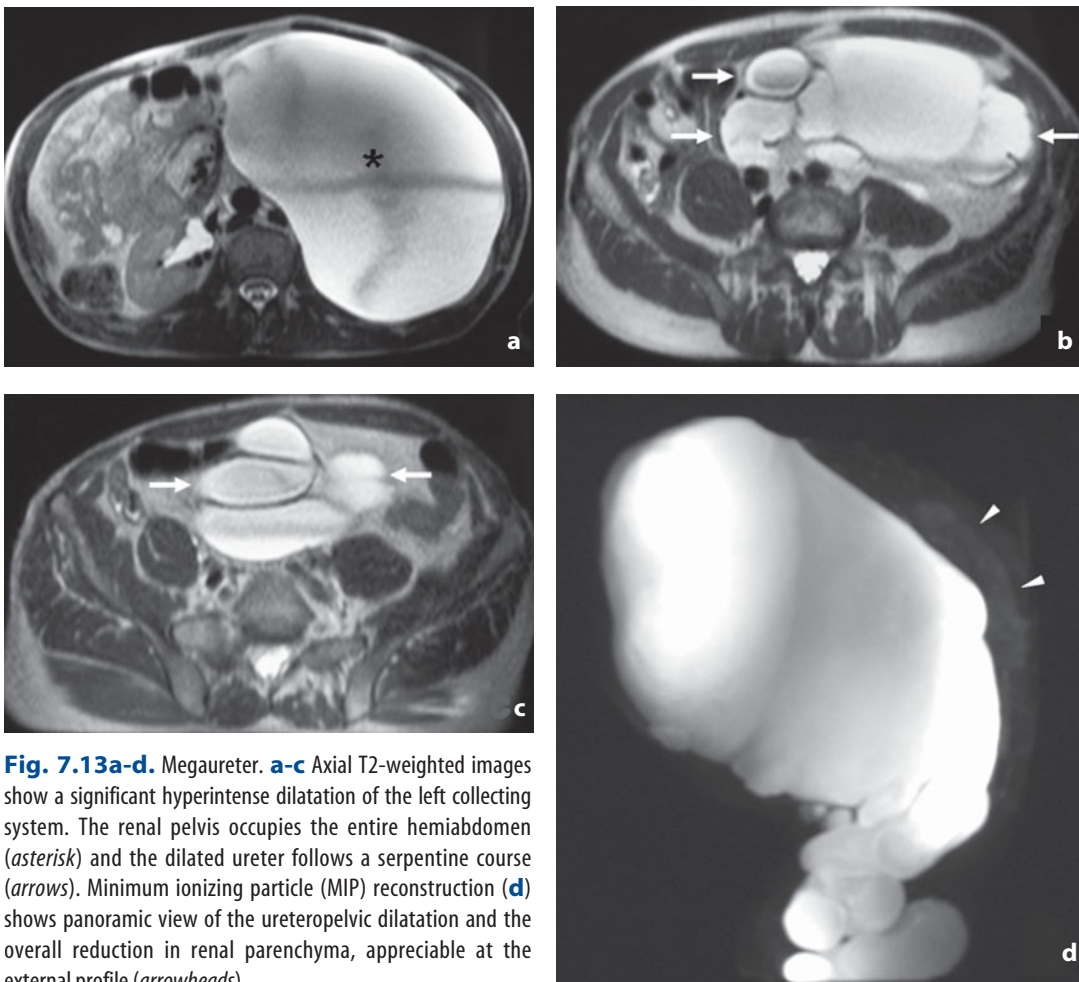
Megaureter. a-c Axial T2-weighted images show a significant hyperintense dilatation of the left collecting system. The renal pelvis occupies the entire hemiabdomen (*asterisk*) and the dilated ureter follows a serpentine course (*arrows*). Minimum ionizing particle (MIP) reconstruction (d) shows panoramic view of the ureteropelvic dilatation and the overall reduction in renal parenchyma, appreciable at the external profile (*arrowheads*)
